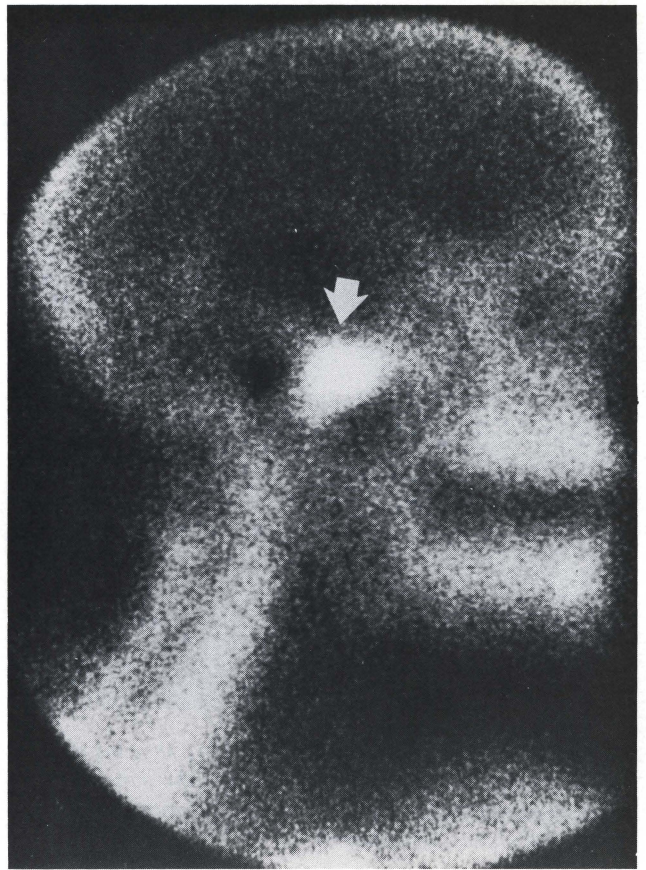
Preoperative lateral scintigram showing increased activity in the right temporomandibular joint (arrow). The dark area posterior represents the external auditory canal.
